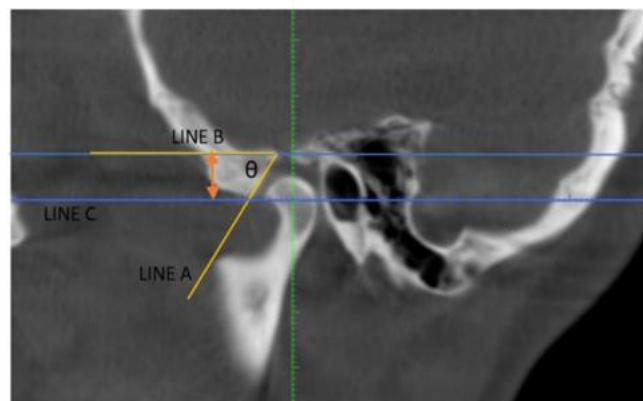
Assessment of articular eminence height and inclination on sagittal CBCT section
